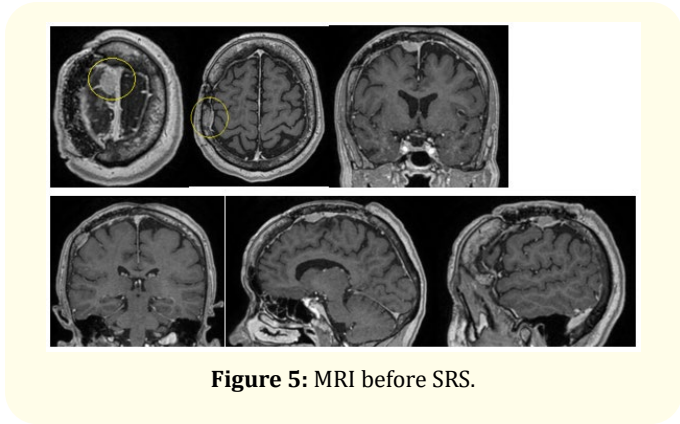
MRI before SRS.
